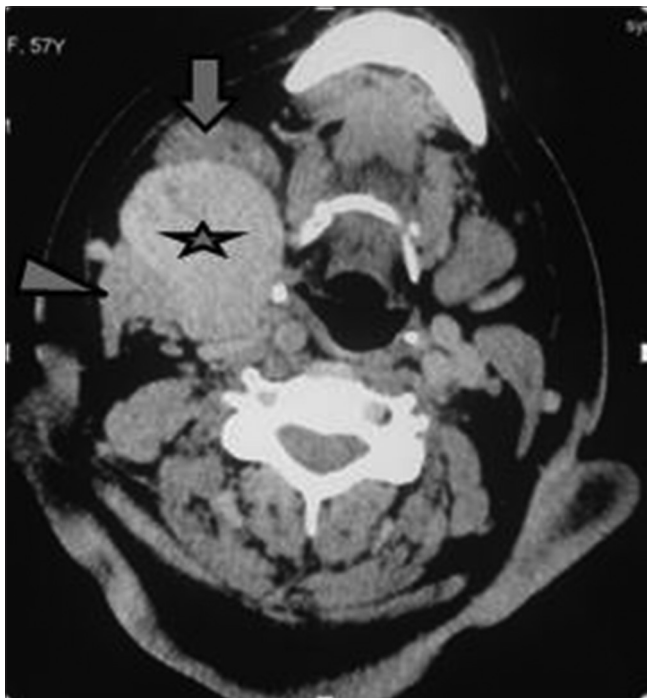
Postcontrast axial computed tomography image shows an intensely enhancing submandibular mass lesion (star) seen in between right submandibular gland (arrow) and right sternocleidomastoid muscle (arrowhead)
